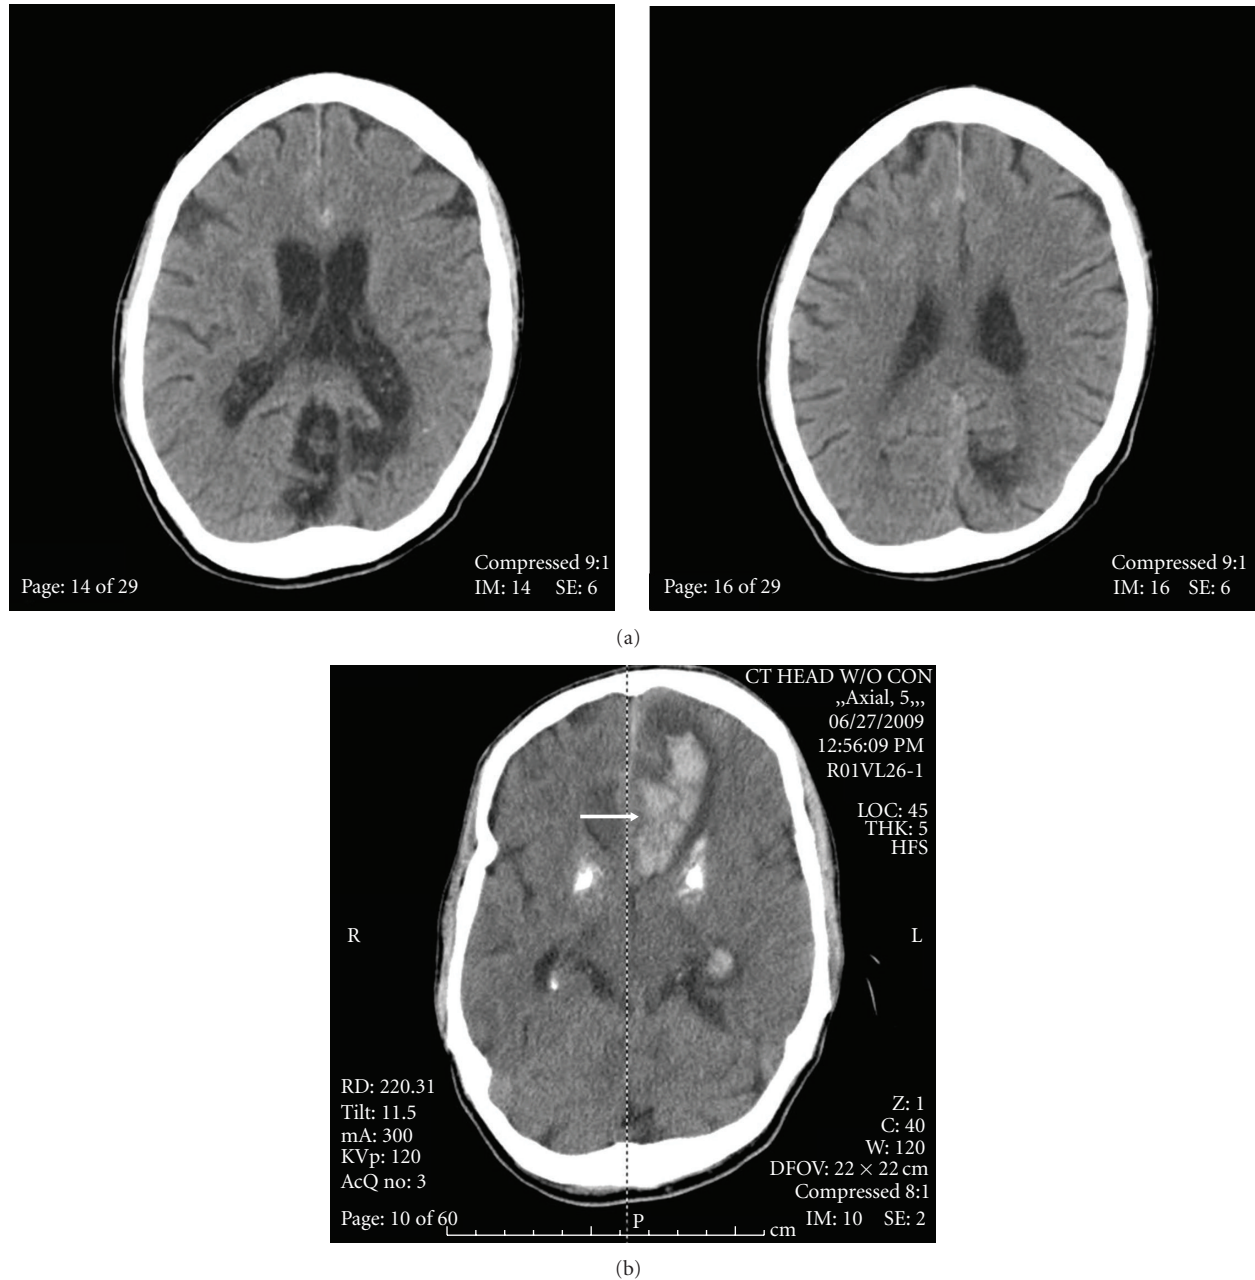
Progression of the ruptured Mycotic Aneurysm: (a) initial subarachnoid hemorrhage after 6 days IV antibiotics. Note interhemispheric hemorrhage. (b) Repeat noncontrast CT Brain 12 hours later, intraparenchymal hemorrhage is marked by arrow. Note prominent basal ganglia calcifications.
